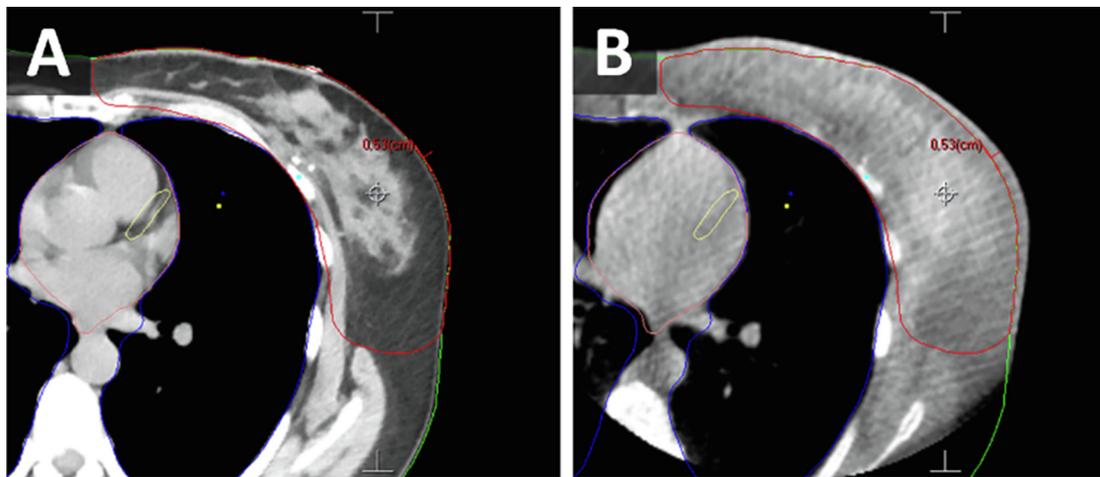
(A) Planning CT and (B) corresponding CBCT of one fraction in one left sided patient.
